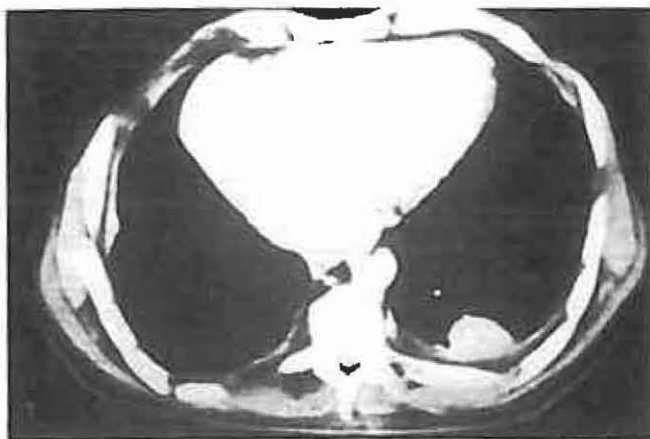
Chest CT of patient in Figure 26, showing left-sided posterior mass found at resection to be a well-differentiated adenocarcinoma.
